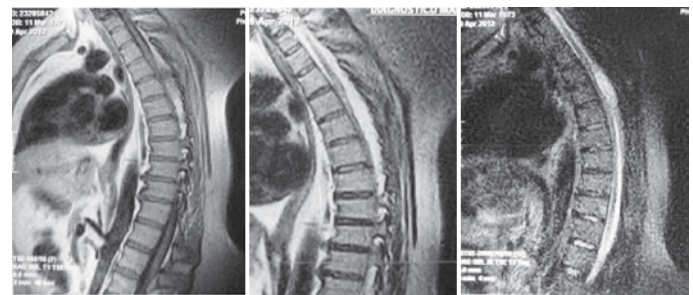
MRI sagittal section of the sequence T1, T2, and T2 with fat suppression.
